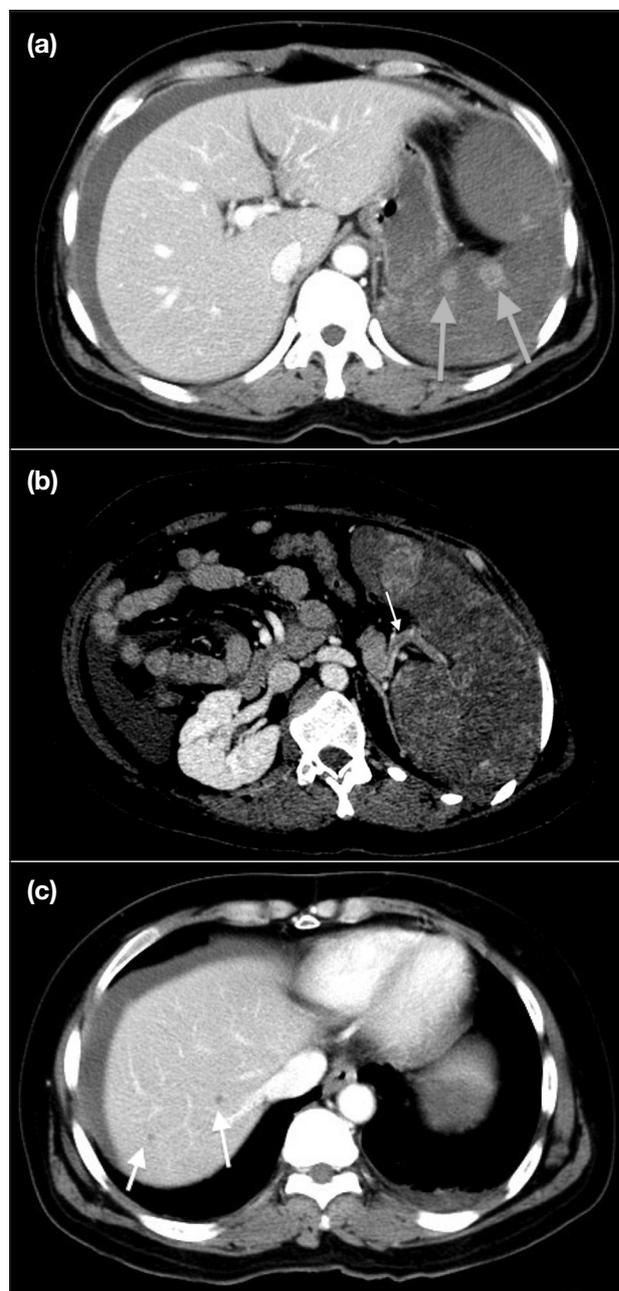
Computed tomography scans of the abdomen and pelvis showing (a) enhancing nodules within the enlarged spleen (arrows); (b) splenic vein thrombosis (arrow); and (c) non-specific hypodense lesions in the right lobe of the liver (arrows).
